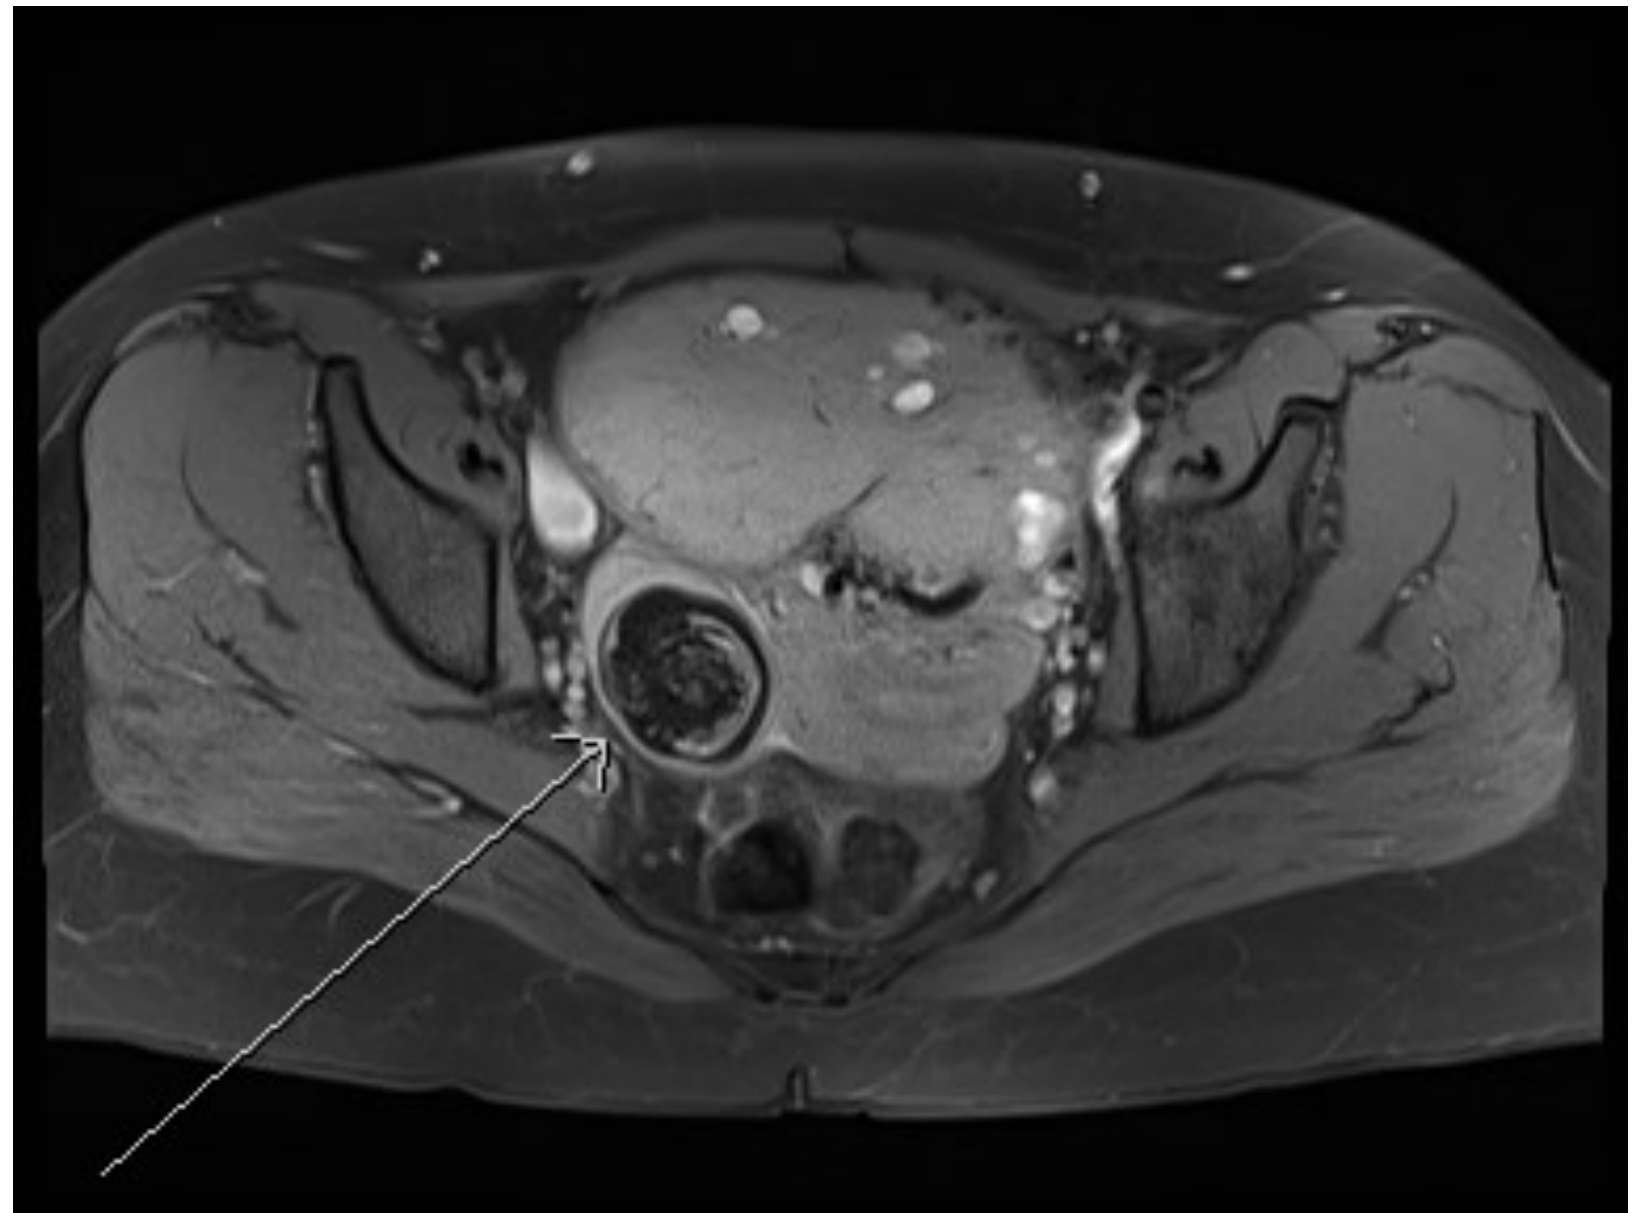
MRI image demonstrating pelvic mass and right sided cystic lesion
